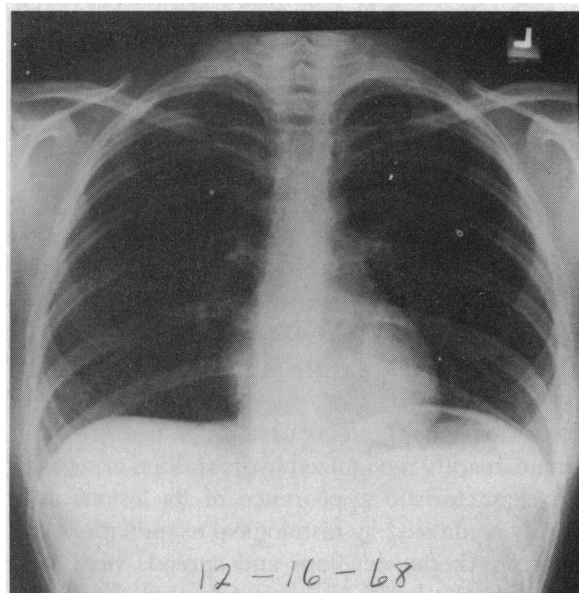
Postoperative x-ray film shows no abnormality of position or tension of organs.
